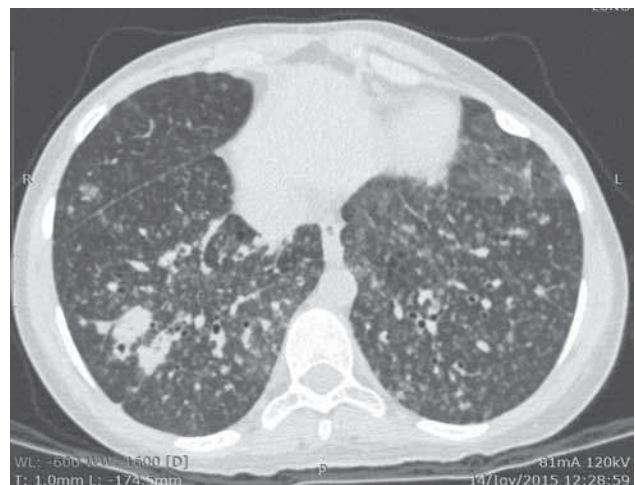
CT reveals reticulonodular opacities in the lower part of right lung.
